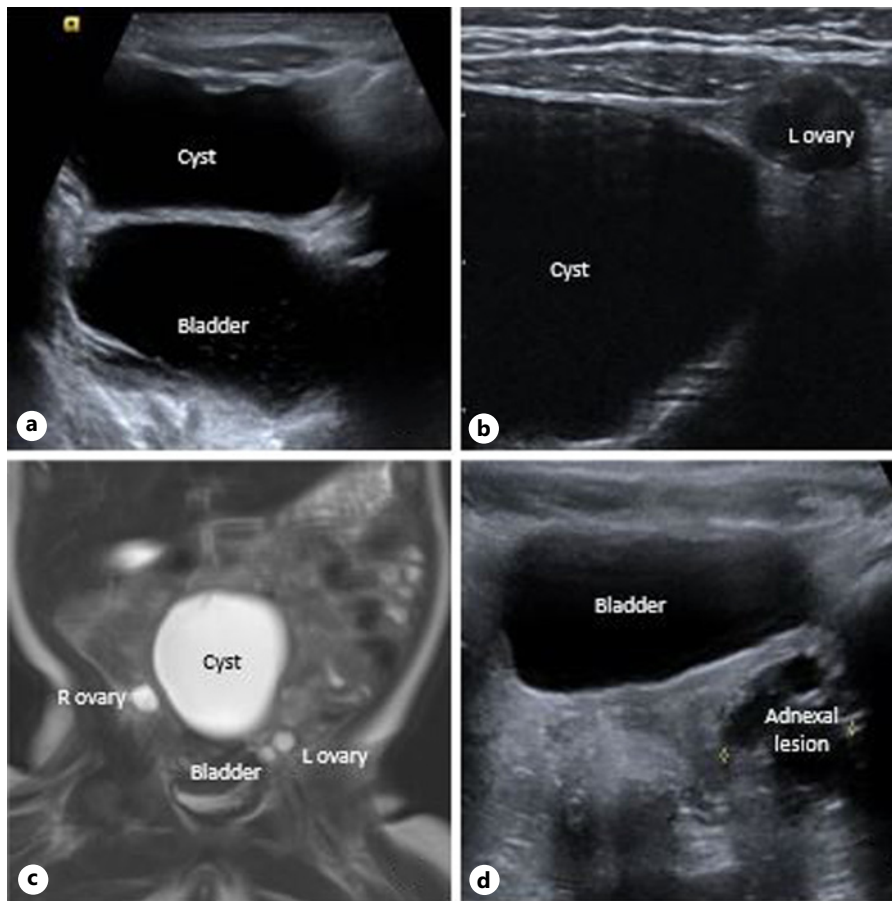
a Midline pelvic cystic lesion superior to the bladder on pelvic ultrasound. b Cyst noted to be separate from left ovary on pelvic ultrasound (right ovary not pictured). c Cyst identified in the retroperitoneum and identified as separate from both ovaries and the bladder on T2-weighted MRI. d Multicystic lesion in left adnexa on pelvic ultrasound.
